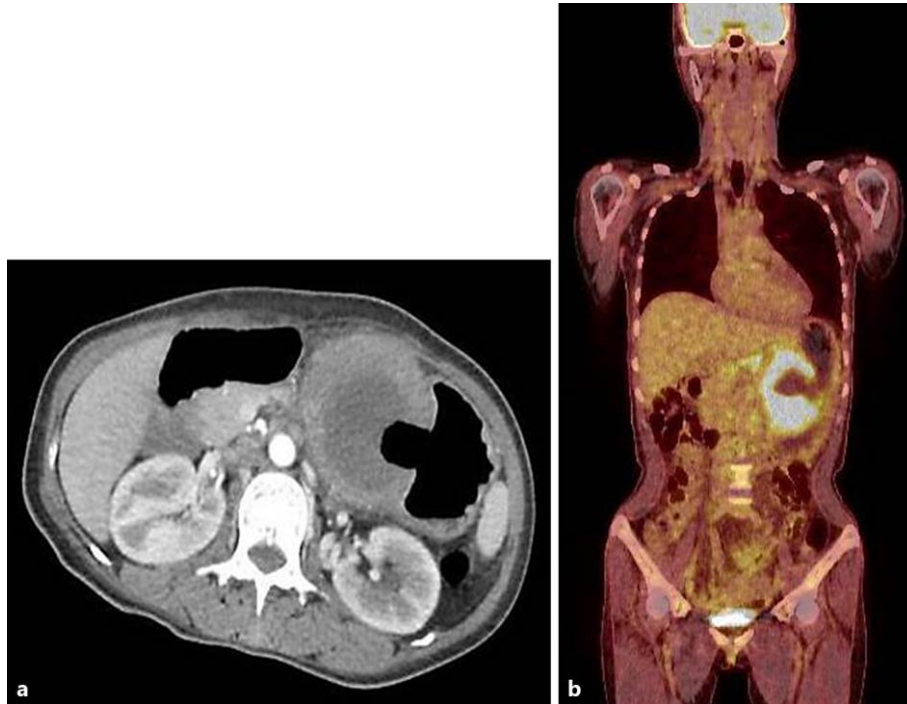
a Stomach CT demonstrated a 9.6-cm subepithelial mass with internal necrosis ulcer abutting the gastric lesser curvature. b ^{18}F -FDG PET/CT showed a 9.6-cm FDG-avid lesion in the gastric midbody and FDG-avid lymph nodes in the left gastric, aortocaval, left paraaortic and left supraclavicular areas.
